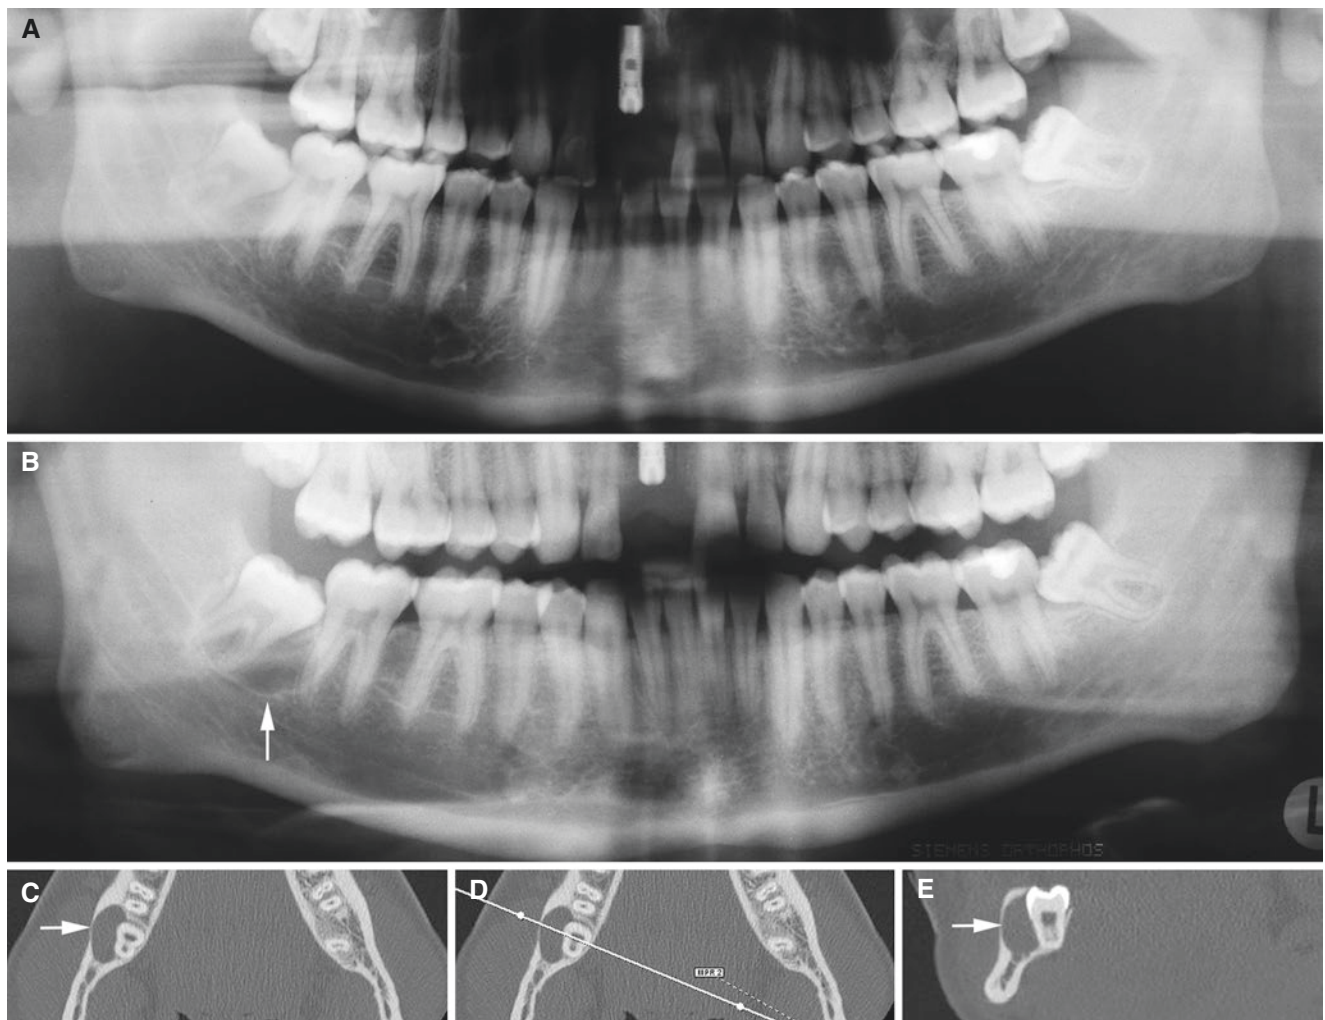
Paradental cyst, mandible; 18-year-old female with routine dental radiography of implant in the maxilla. (A) Panoramic view shows normal bone at right mandibular wisdom tooth. (B) Panoramic
